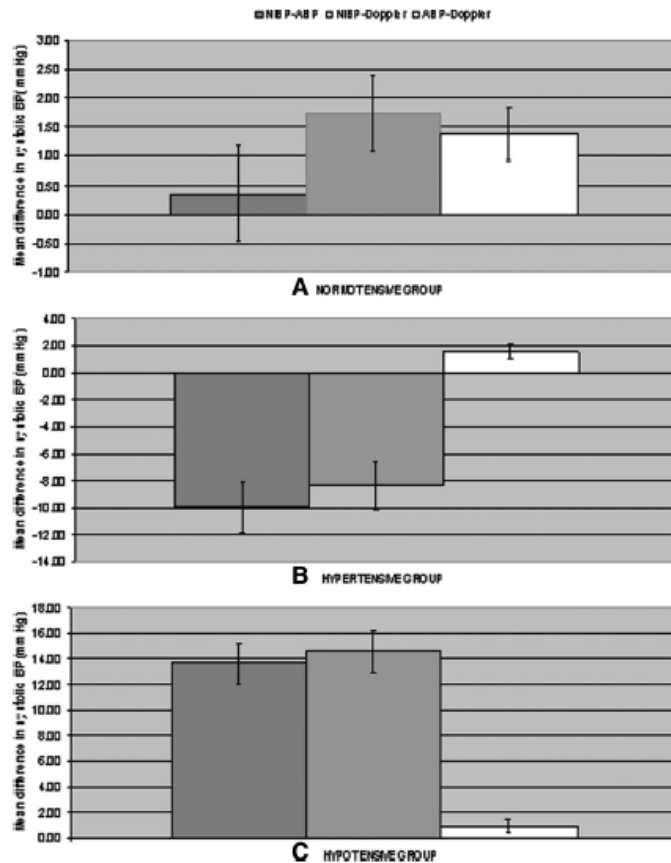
Difference in systolic arterial blood pressure between methods (indirect blood pressure using the Phillips automated oscillometric device [NIBP]–arterial blood pressure [ABP], NIBP–Doppler ultrasound, and ABP–Doppler ultrasound): mean and SE of mean (mm Hg). A, Normotensive; B, hypertensive; C, hypotensive subjects.
